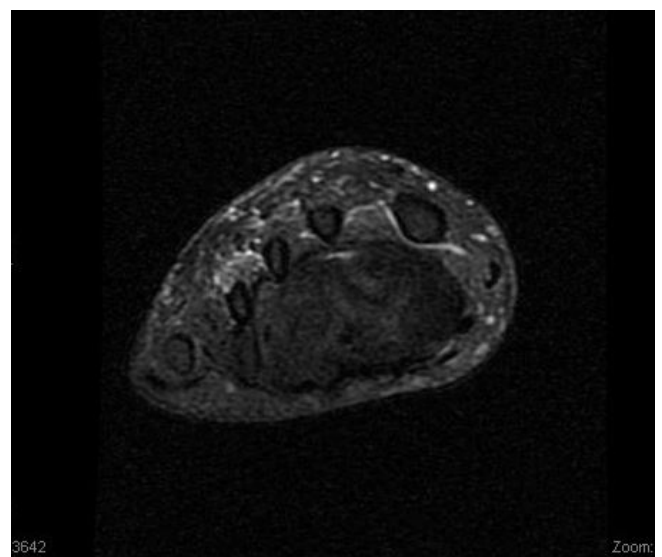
MRI coronal view right foot.
